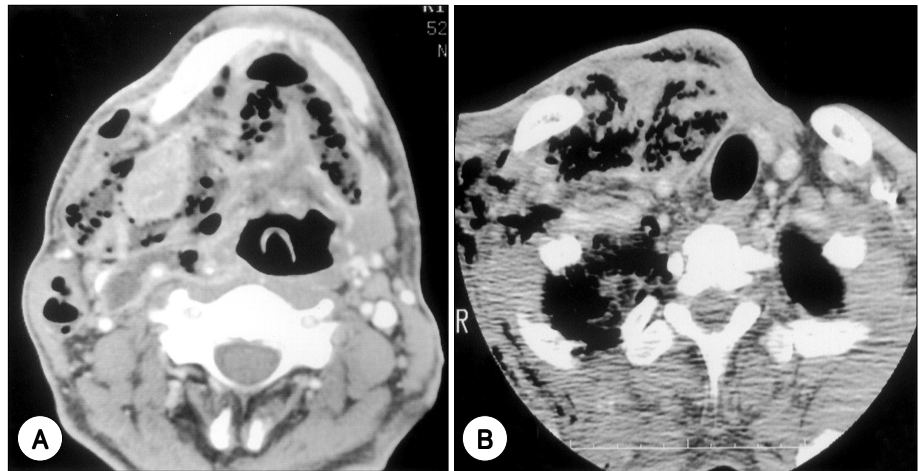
A and B : Computed tomography scan with contrast in the axial plane demonstrates progressive multiple abscess with air in multiple neck space (in case 4).
